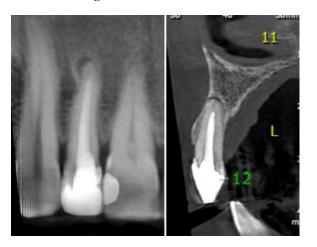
Initial computed tomography
